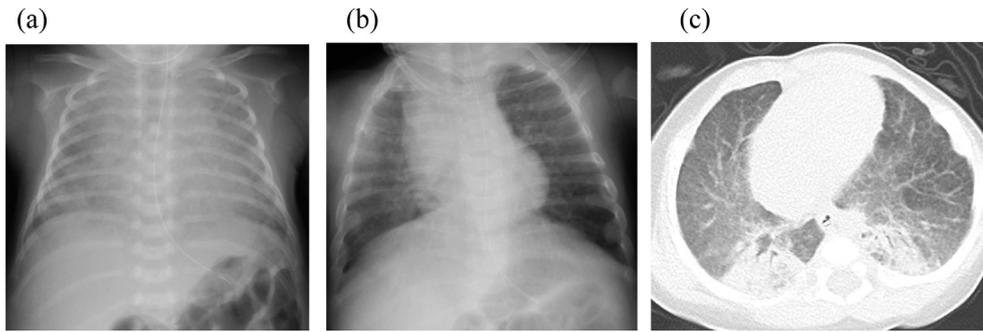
a) Chest radiograph at diagnosis. An infiltrative shadow and heart enlargement were detected. b) c) Chest radiograph and CT image at discharge. The infiltrative shadow on chest radiograph showed improvement. Chronic aspiration was suspected due to consolidation of the bilateral posterior lung field on chest CT scan.
